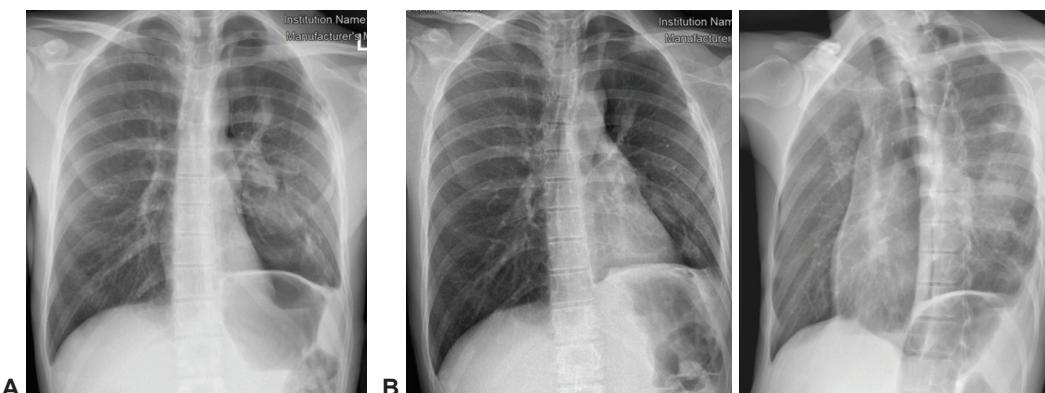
Chest X-ray: A – on the 13th postoperative day, B – on the 26th postoperative day
